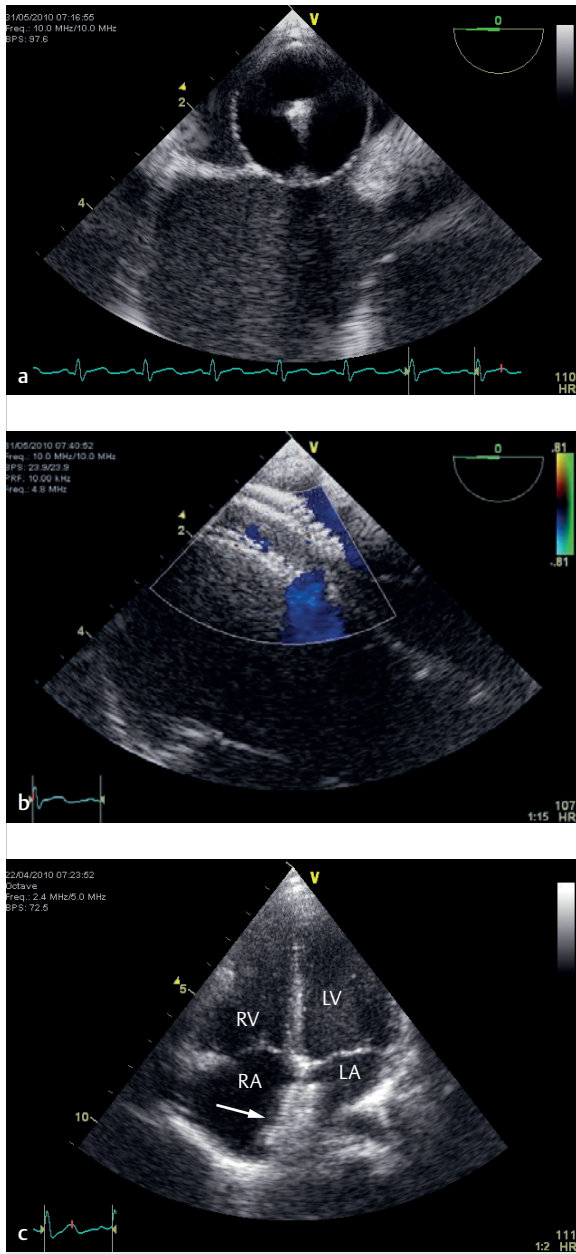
Echocardiographic ASD closure.
